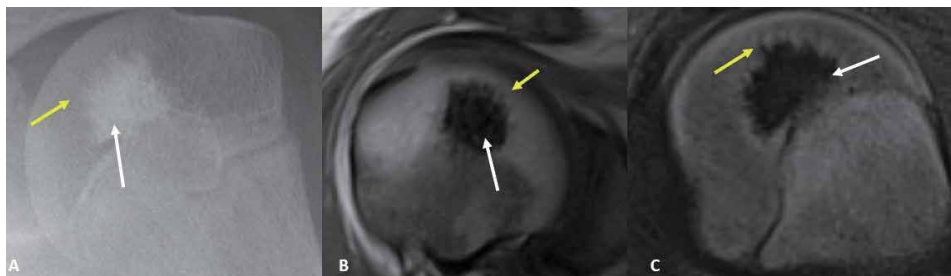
Enostosis: Frontal radiograph of left humerus (A) shows a circumscribed focal sclerosis (white arrow) in the proximal epiphysis with peripheral brush border extensions into the normal adjacent bone. Axial T1-weighted (B) and T2-weighted fat-saturated (C) images reveal marked hypointense signal of the bone island.
